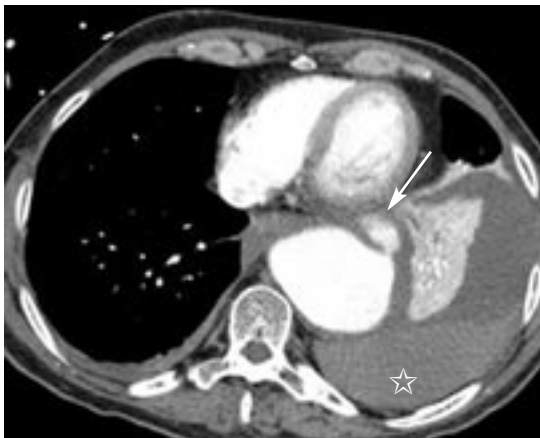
Axial image from contrast-enhanced, cardiac-gated CT in a patient with acute aortic syndrome and hypotension demonstrates aneurysmal dilatation of the descending thoracic aorta with a contained aortic rupture anterolaterally (arrow). A layering left hemothorax is also visible (star). The patient underwent urgent endovascular stent repair.
